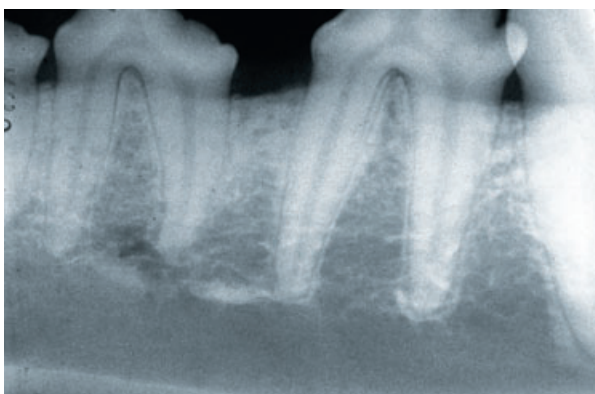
Radiograph obtained from the premolars in the left side of the mandible.
